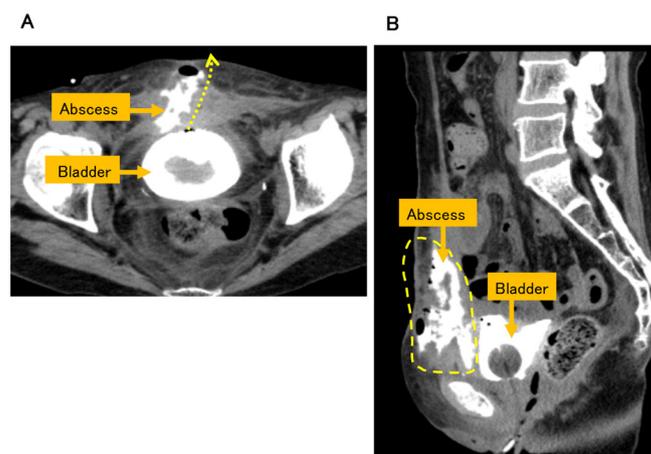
CT image after cystography. Contrast medium was observed flowing into the abscess cavity in the space of Retzius. These findings were consistent with urine leakage from bladder perforation/rupture through the abscess cavity to the surgical wound.
